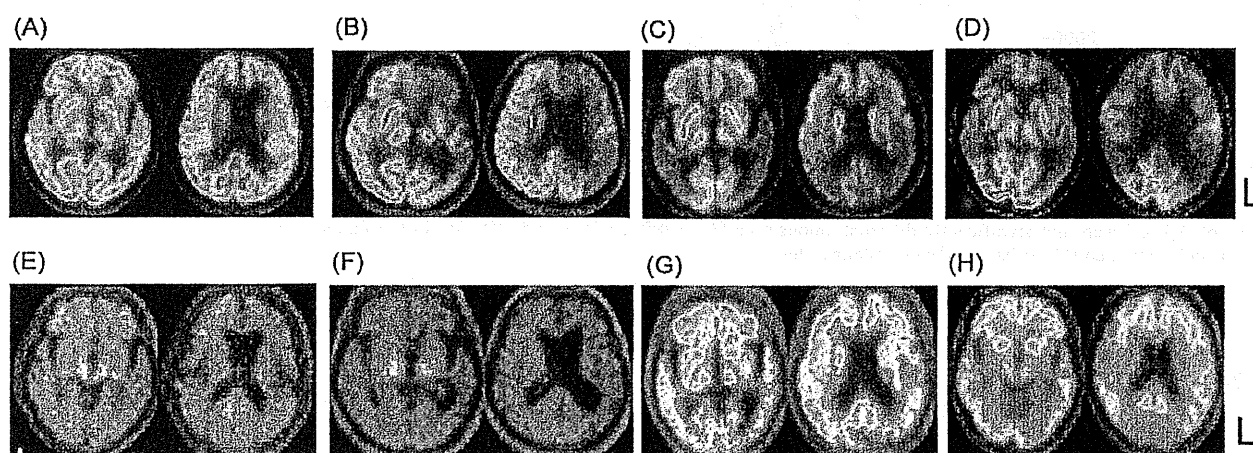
FDG-PET and  $^{11}\text{C}$  PiB-PET. (A) In naPPA patients, FDG-PET analysis showed glucose hypometabolism in the left posterior fronto-insular region. (B)  $^{11}\text{C}$  PiB-PET showed no abnormal signal lesion in the brain of naPPA patients. (C) In svPPA patients, FDG-PET showed glucose hypometabolism in the left anterior temporal lobe, while no PiB positive signal finding in cerebral cortices (D). (E) While lvPPA patients showed glucose hypometabolism in the left anterior temporal lobe by FDG-PET,  $^{11}\text{C}$  PiB-PET showed abnormal high PiB signal findings in cerebral cortices of frontal lobes and temporal lobes and the posterior cingulate (F). (G) An early-onset AD patient showed glucose hypometabolism in bilateral frontal and temporal lobes, presenting abnormal PiB positive signal findings in cerebral cortices and the posterior cingulate in  $^{11}\text{C}$  PiB-PET (H).
